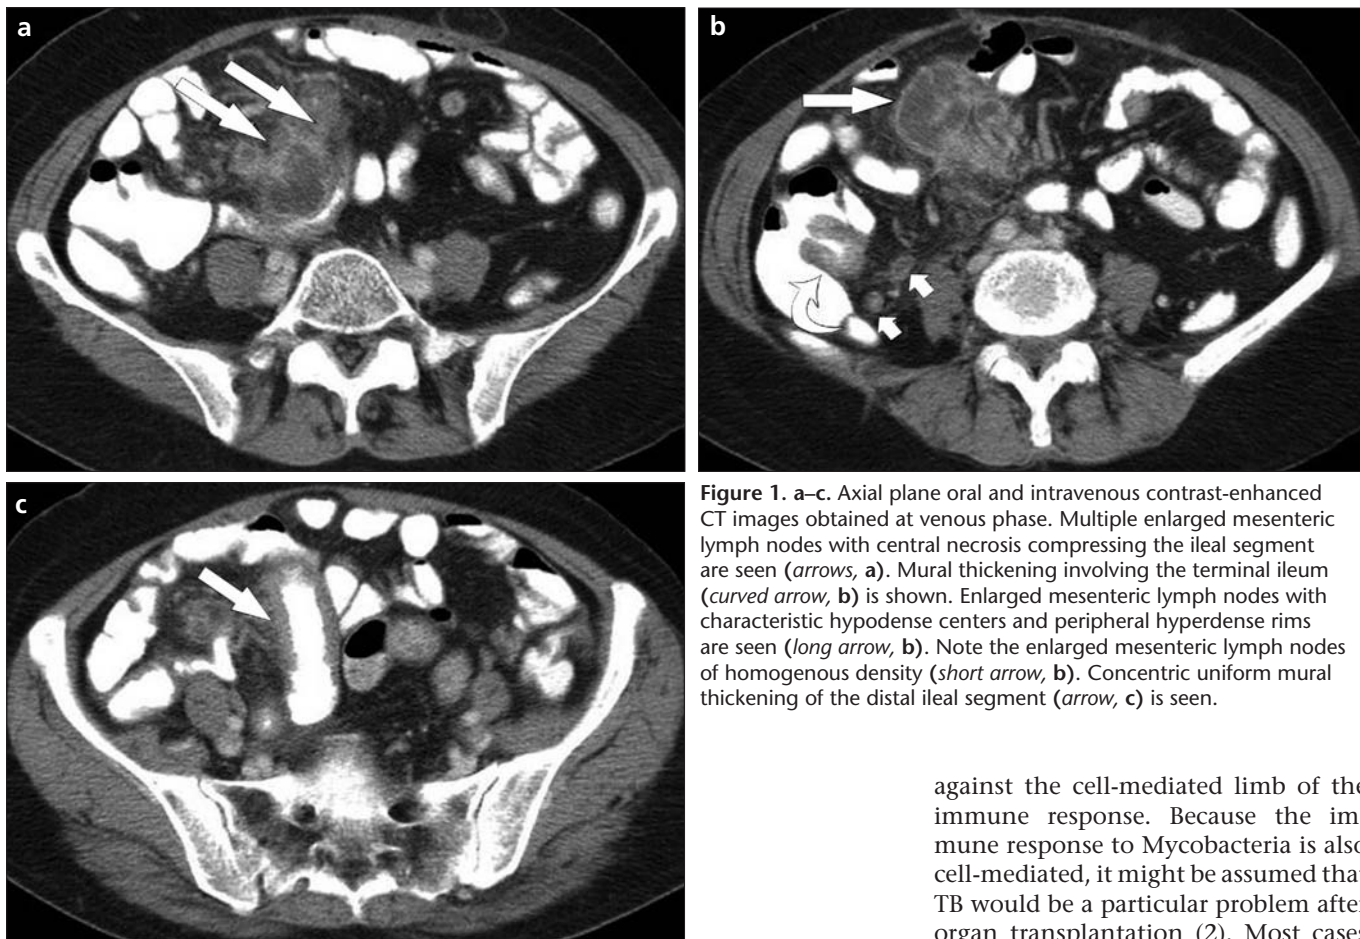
a–c. Axial plane oral and intravenous contrast-enhanced CT images obtained at venous phase. Multiple enlarged mesenteric lymph nodes with central necrosis compressing the ileal segment are seen (arrows, a). Mural thickening involving the terminal ileum (curved arrow, b) is shown. Enlarged mesenteric lymph nodes with characteristic hypodense centers and peripheral hyperdense rims are seen (long arrow, b). Note the enlarged mesenteric lymph nodes of homogenous density (short arrow, b). Concentric uniform mural thickening of the distal ileal segment (arrow, c) is seen.
